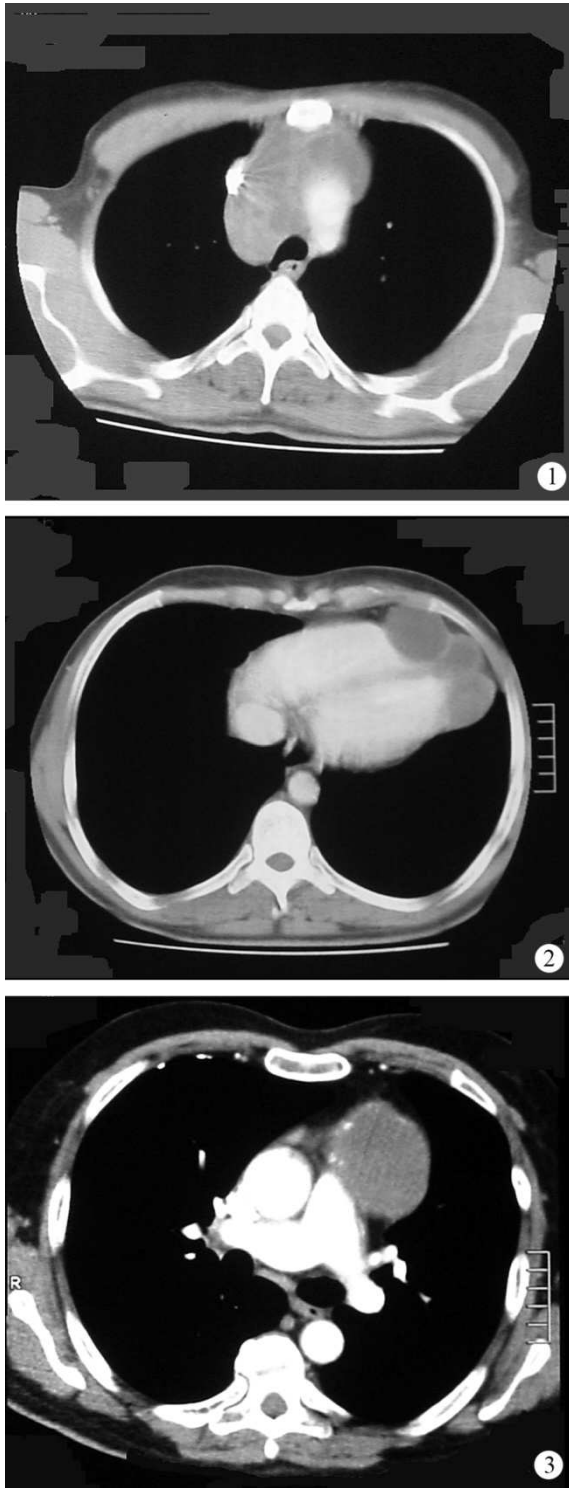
Computed tomography scan demonstrating multiple cystic lesions at anterior mediastinum.
